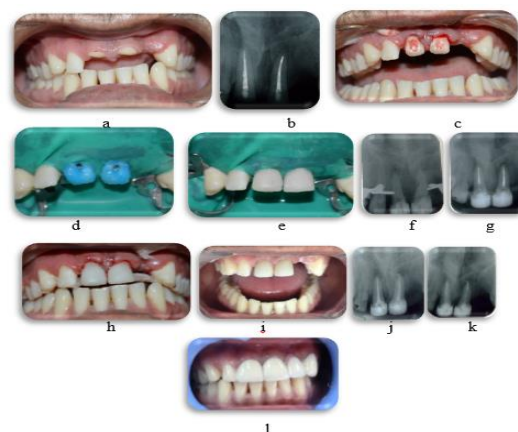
(a) Photograph showing a cervical root fracture of teeth 11,21. Note that the tooth crowns were absent. (b) Pre-operative radiograph of the same teeth. Note that endodontic treatment was started before repositioning and Ca(OH)₂ medicament placed (c) Position of the tooth immediately after surgical extrusion of 4 mm and 180° rotation. (d) isolation achieved and etching of extruded tooth done. (e) esthetic buildup done. (f&g) working length established after buildup and Ca (OH)₂ medicament placed. (h) immediate post op with fiber splint lingually (i) Appearance of the tooth 2 weeks after surgical extrusion. (j) completion of endodontic treatment. (k) Radiograph taken 8 months after endodontic treatment & Fiber post placement. Note the resolution of periapical radiolucency and that there are no signs of root resorption. (l) appearance after final restoration
